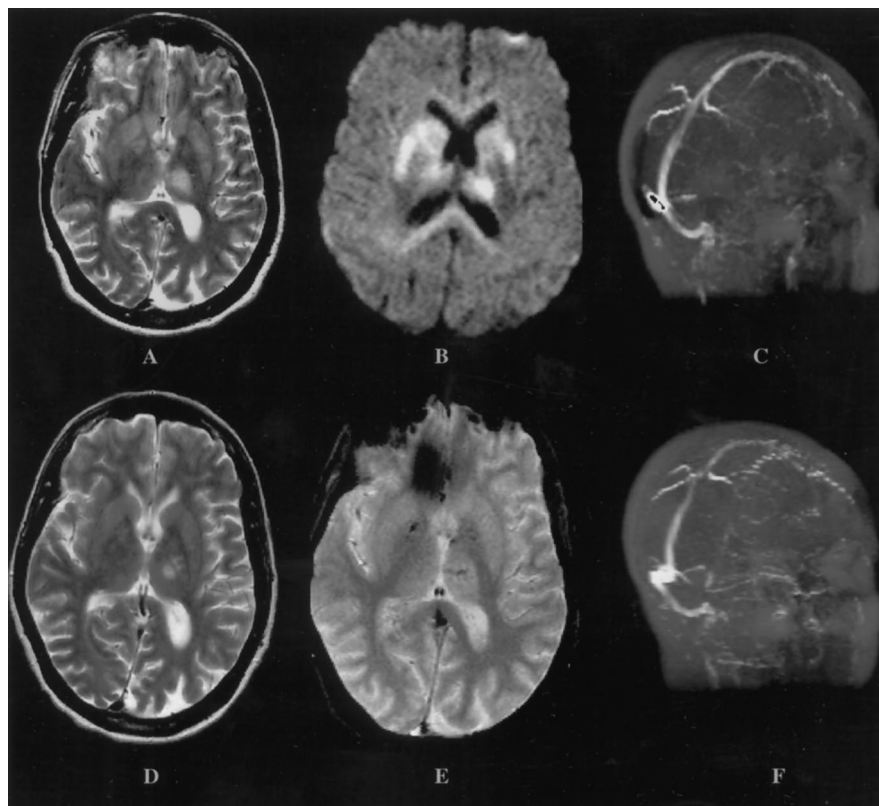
(A) MRI at presentation showing multiple T2 abnormalities. (B) Diffusion-weighted sequence demonstrating marked signal changes in deep structures. (C) Magnetic resonance venography (MRV) showing absent flow in the internal cerebral venous system. (D) A T2-weighted MRI 1 month later showing a few areas of infarction. (E) Susceptibility-weighted sequences demonstrating multiple areas of punctate hemorrhage. (F) MRV 1 month later demonstrating improved flow in the internal cerebral venous system.
